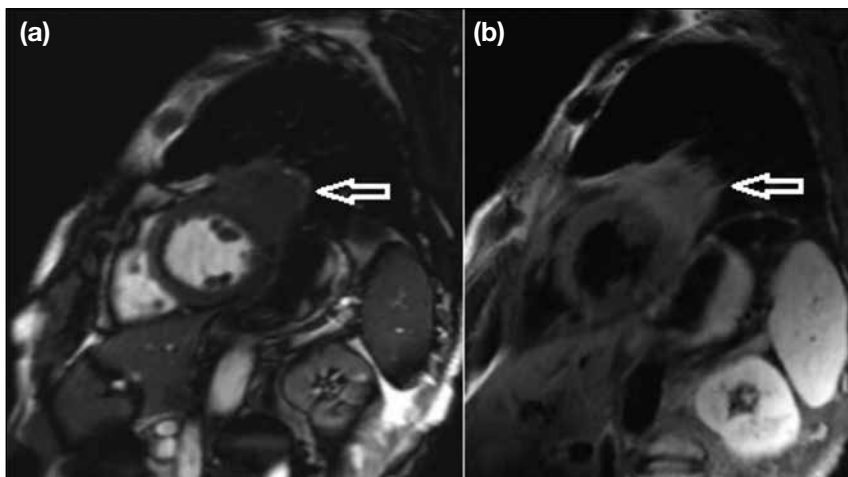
Cardiac magnetic resonance images showing the same lesion at two sequences, which is a central lung mass (arrows) with a broad base and direct invasion to the heart causing loss of the normal myocardial signal at the outermost part of the left ventricle. The patient had no cardiac symptoms. (a) Short-axis cine steady-state free precession gradient echo sequence. (b) Short-axis phase-sensitive inversion recovery sequence with late gadolinium enhancement.
